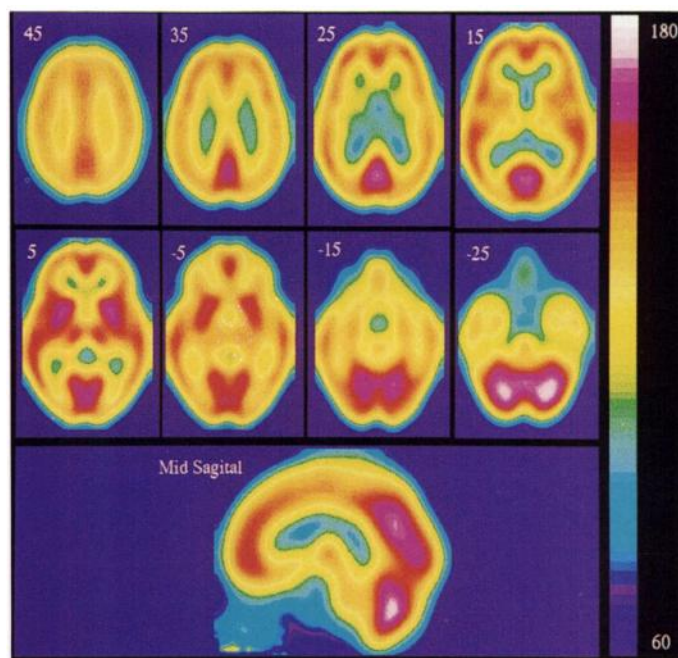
Mean of realigned ^{99m}Tc -HMPAO SPECT images. The mean global value is 100 counts/pixel. All slices, except that at the bottom, are parallel to the horizontal plane through the intercommissural line (the top left image is 45 mm above the intercommissural line, and the following pictures were taken at 10-mm intervals). The anterior is on the top of the image, and the subject's right is on the left. The mid-sagittal section is shown at the bottom.
